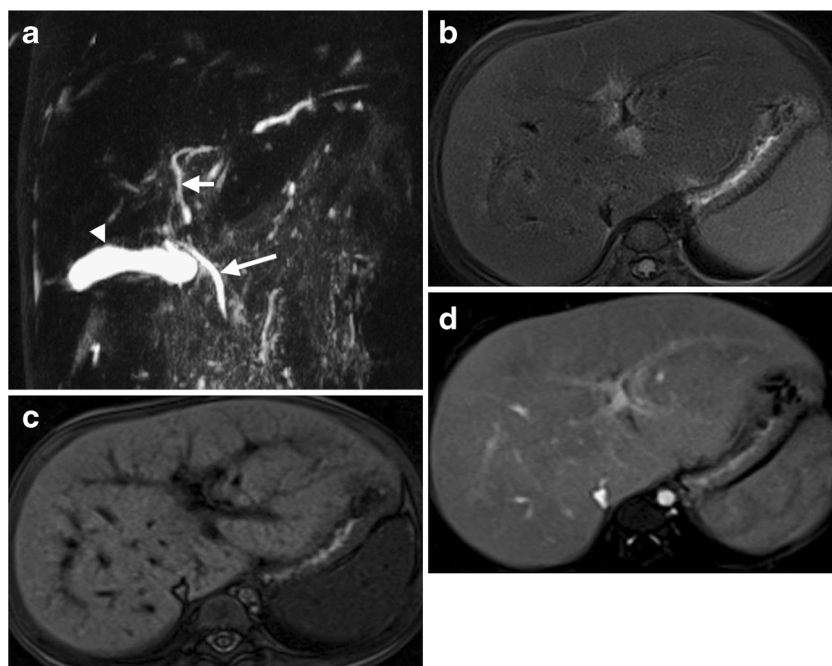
MRCP and CT in a 4-year-old girl (patient 8). a MRCP demonstrates multiple dilations and stenoses of the common hepatic duct and its branches. Multiple cystic-like lesions along the intrahepatic biliary system can be seen, and there is a large gallbladder. Note the common bile duct (*long arrow*), the left hepatic duct branch (*short arrow*) and the right
